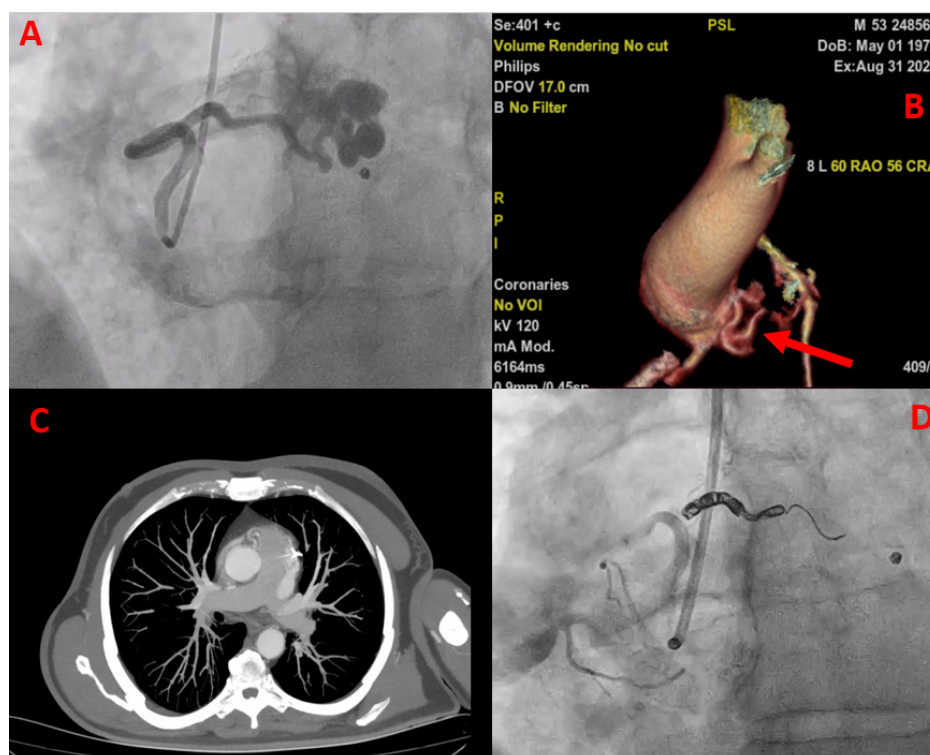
A) Aortopulmonary fistula detected by coronary angiography. B) Three-dimensional computed tomography (CT) angiography demonstrating the origin and course of the aortopulmonary fistula (arrows). C) Two-dimensional CT angiography showing the connection of the fistula to the main pulmonary artery (arrow). D) Angiographic image after percutaneous coil embolization demonstrating complete occlusion of the fistula
